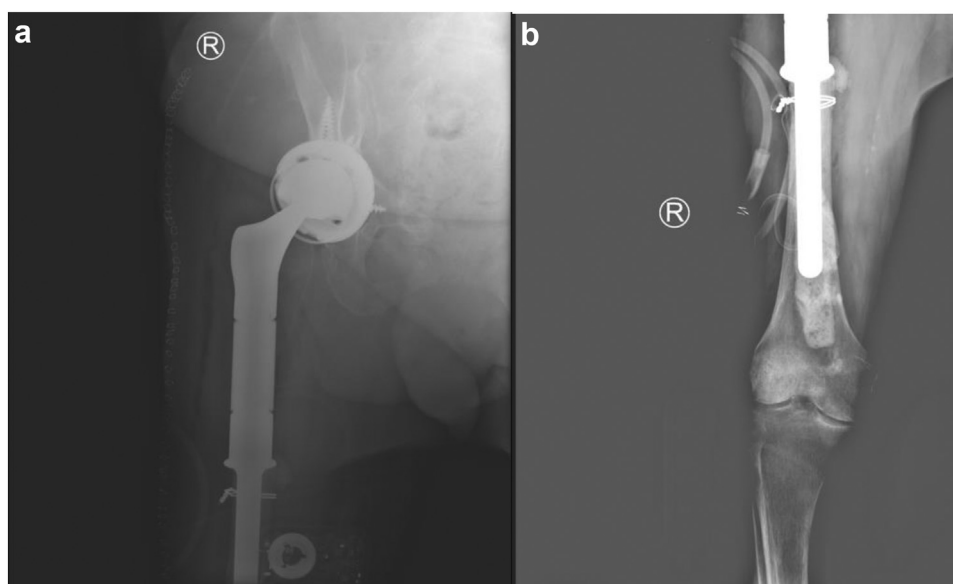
Final postoperative radiographs after proximal femur replacement. (a) Eight-week postoperative anterior-posterior definitive fixation of right hip radiograph demonstrating proximal femur replacement with multihole acetabular-constrained component. (b) Eight-week postoperative anterior-posterior definitive fixation of right femur radiograph demonstrating the distal aspect of proximal femur replacement with cerclage wiring and cement mantle within the distal femur.
